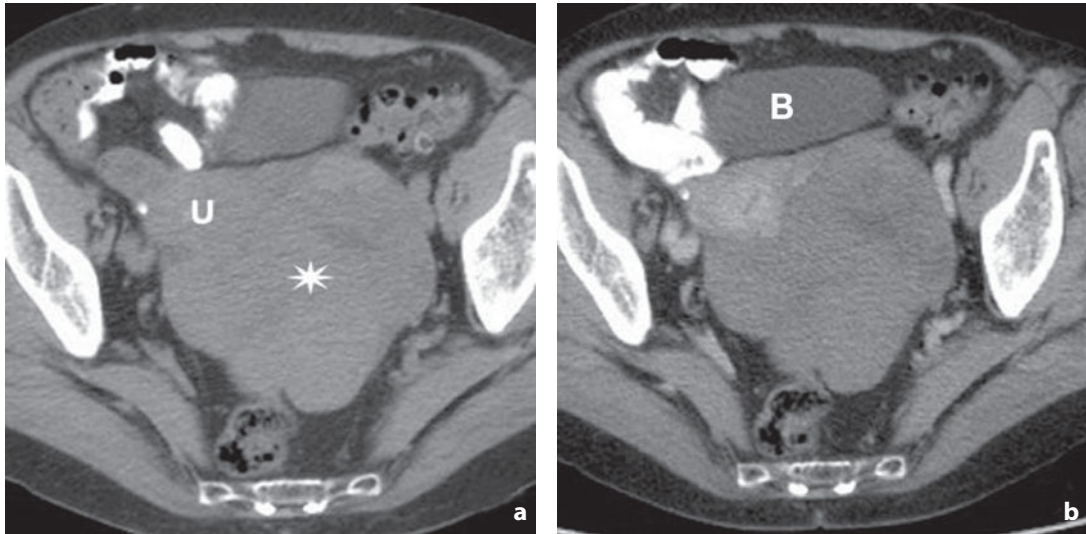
Computed tomography. Fibrothecoma. a Nonenhanced examination. Multilobular left adnexal mass (*asterisk*) with sharp smooth margins appearing hypoattenuating to the uterus (*U*). b After contrast medium administration mild heterogeneous enhancement is apparent inferior to the uterus, the fundus of which is shifted anterolaterally to the right. *B*, urinary bladder
